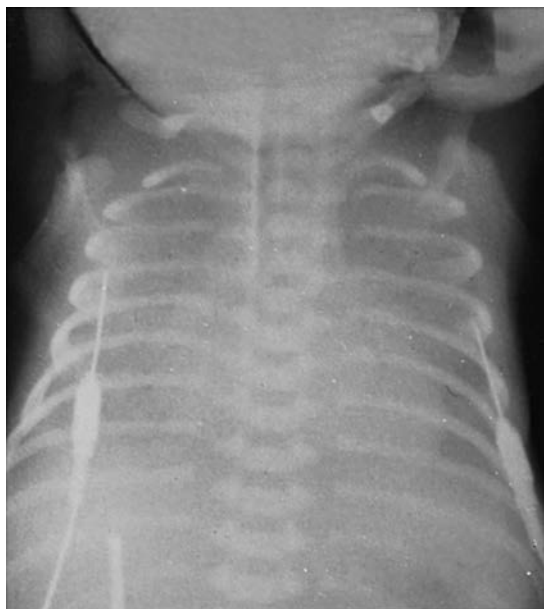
Chest x-ray film of a preterm infant (28 weeks' gestation) with severe respiratory distress syndrome. Note "whiteout" appearance.
